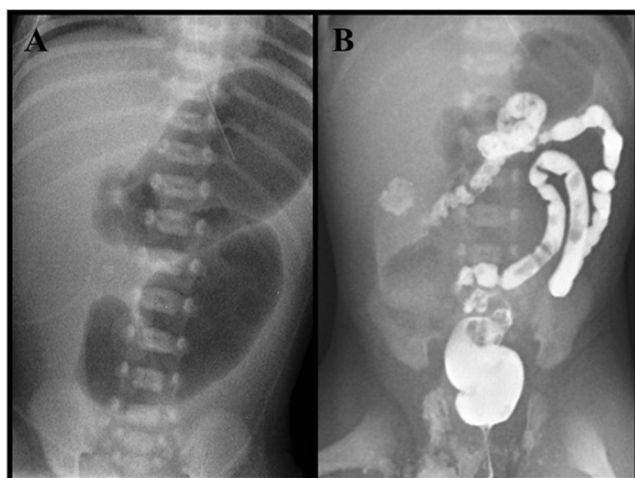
Abdominal X-ray shows the double-bubble sign a. Barium enema reveals disuse microcolon b
